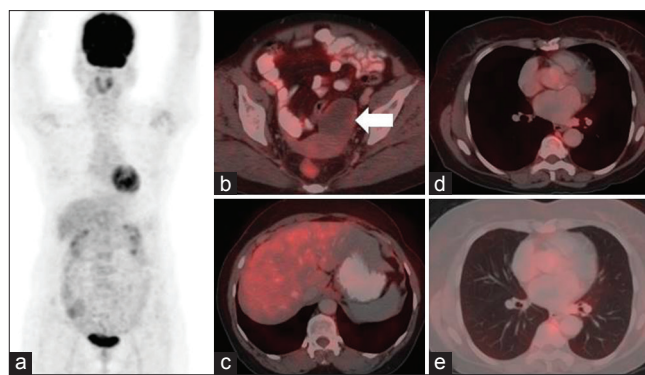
Follow-up whole-body F-18 fluorodeoxyglucose positron emission tomography/computed tomography (a; maximum intensity projection image) shows significant interval reduction in size, extent, and metabolic activity of ovarian mass (b; white arrow) along with near-complete resolution of right pleural and perifissural deposits as well as right pleural effusion (c-e)
